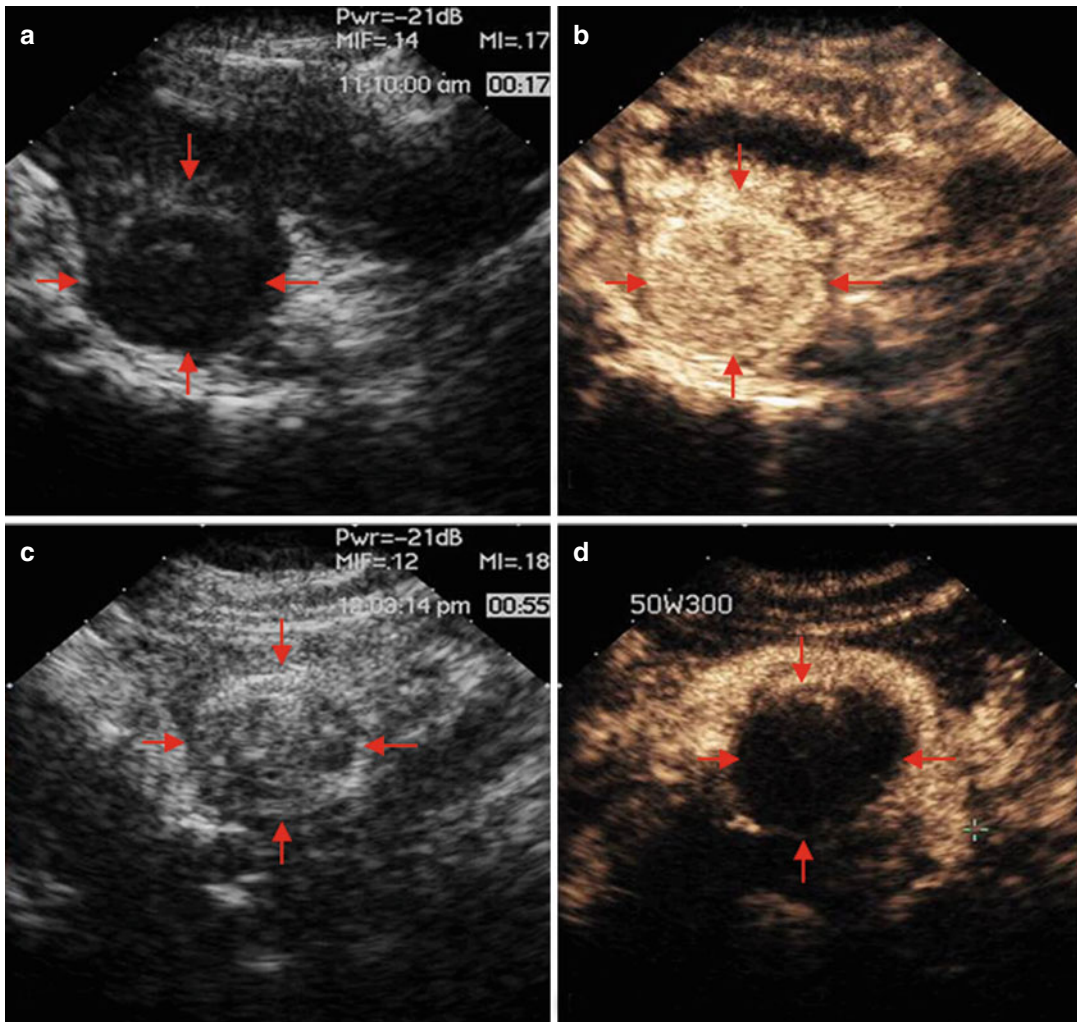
Percutaneous MWA in a 31-year-old woman with a single subserous fibroid in posterior uterine wall. (a) Preablation two-dimensional gray-scale ultrasonography shows the hypoechoic fibroid (arrows) with the size of 4.4×4.9 cm. (b) Pre-contrast-enhanced ultrasonography scan obtained during the early phase after contrast injection, and at 17 s it shows homogeneous hyper-enhancement
